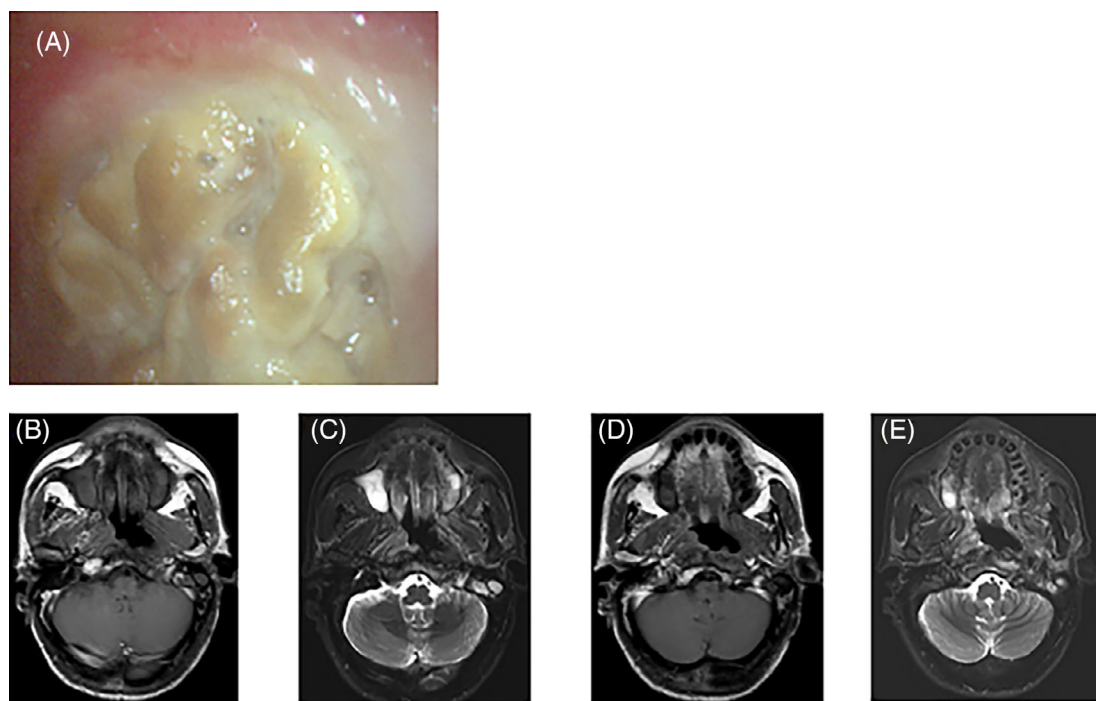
MRI for one patient with T4N1M0. The patient had undergone 2 cycles of neoadjuvant chemotherapy and 2 cycles of concurrent chemotherapy. A, RINU were observed by nasopharyngoscopy. B–E, Transverse contrast T1-weighted and T2-weighted MRI revealed an irregular nasopharyngeal cavity and destruction of the soft tissue, with the formation of large ulcer on the left posterior wall of the nasopharynx
